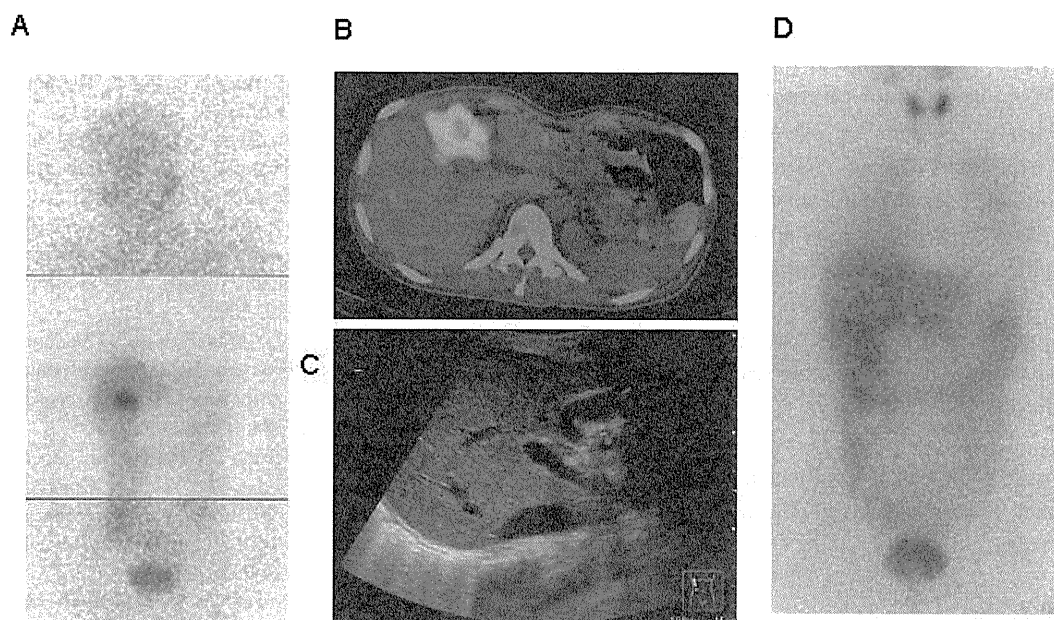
False-positive accumulation of MIBG in the gallbladder. There is clear accumulation of ^{131}I -MIBG in the right upper abdomen (A), which corresponds to the gallbladder, as shown in SPECT (B). There was no detectable tumor in or near the gallbladder on ultrasound (C). ^{123}I -MIBG scintigraphy taken 14 days after ^{131}I -MIBG showed no abnormal accumulation (D).
